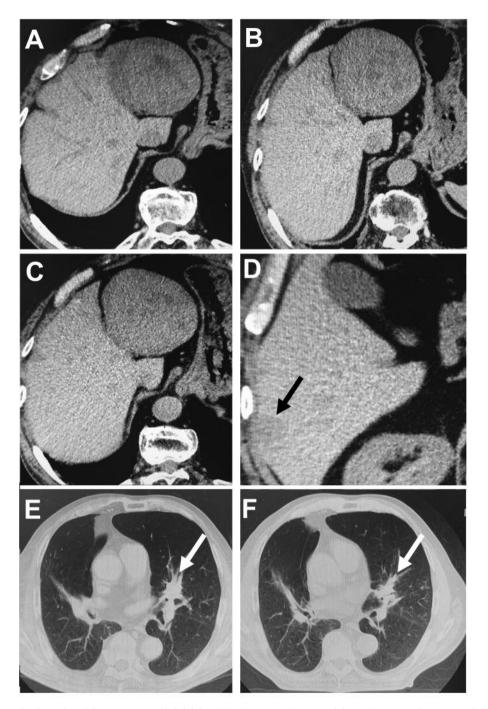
Case 1. (A) CT showed an 8.0 cm tumor in the left lobe of the liver. (B) The sizes of the HCC remained constant after three months. The main HCC tumor enlarged to 9.0 cm (C), and multiple intrahepatic metastases appeared in the right lobe (arrow) after nine months (D). (E) Lung cancer recurrence was detected at the left pulmonary hilum (arrow). (F) It remained constant after three months (arrow).
